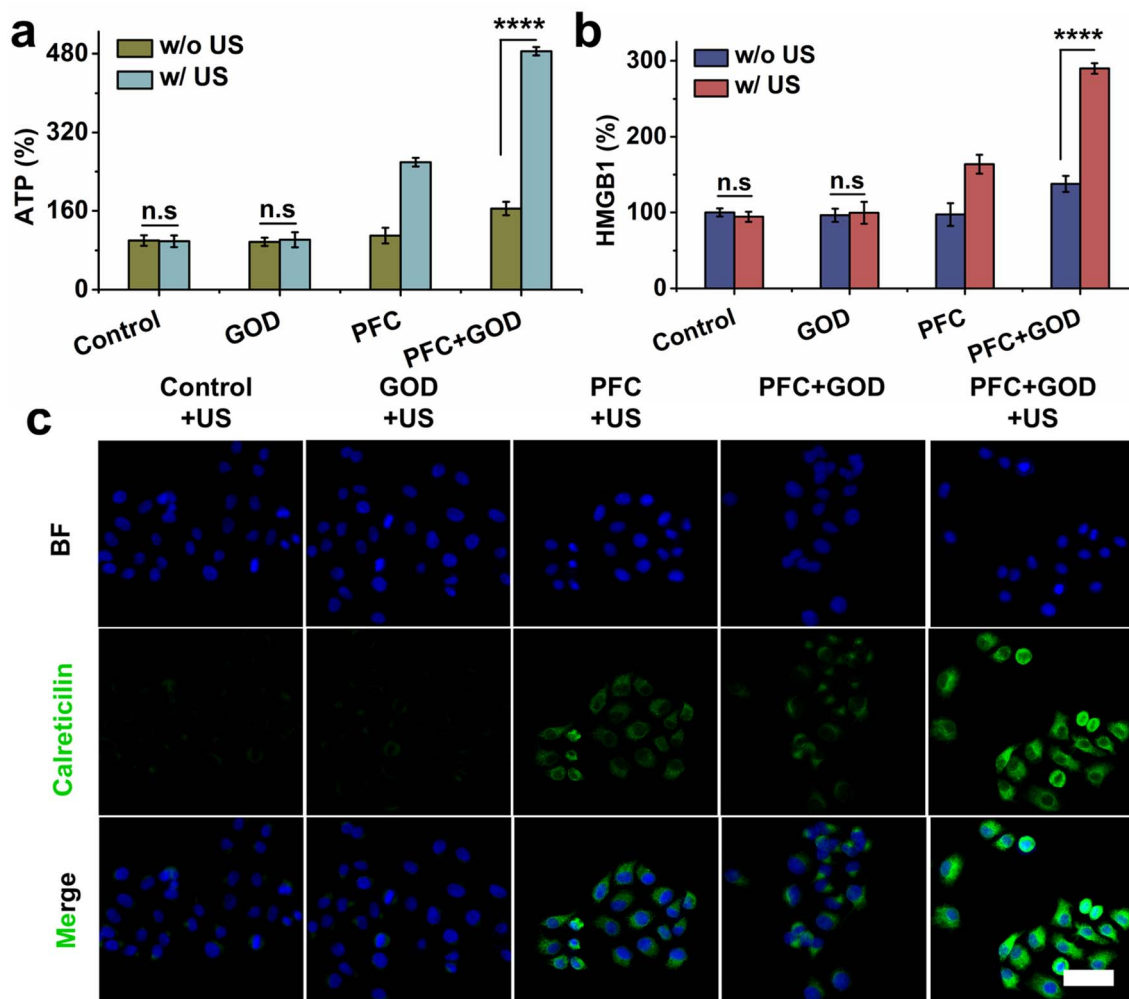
PFC-mediated mechanisms of immunogenic cell death. Percentage of (a) ATP and (b) HMGB1 secreted into the extracellular environment by 4T1 cells after incubation with different materials with or without ultrasonication. (c) Confocal fluorescence imaging of calreticulin released into the extracellular environment by 4T1 cells under different treatments. Scale bar: 50  $\mu\text{m}$ .
